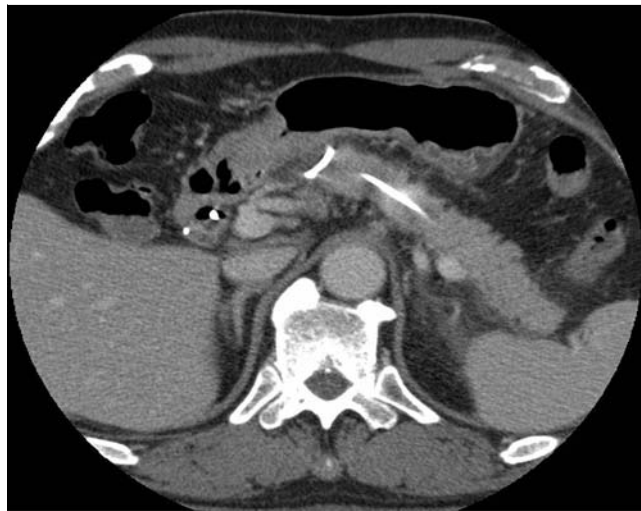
Computed tomography (CT) image showing the proximally migrated pancreatic stent with its pigtail end impacted in a branch of the pancreatic duct.
